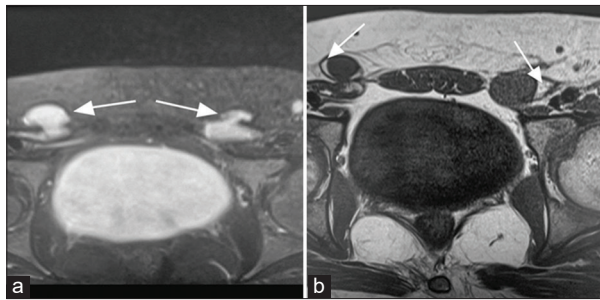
(a) Axial T2-weighted imaging, fat sat, and (b) shows T1-weighted imaging showing bilateral ovaries in the inguinal canal
